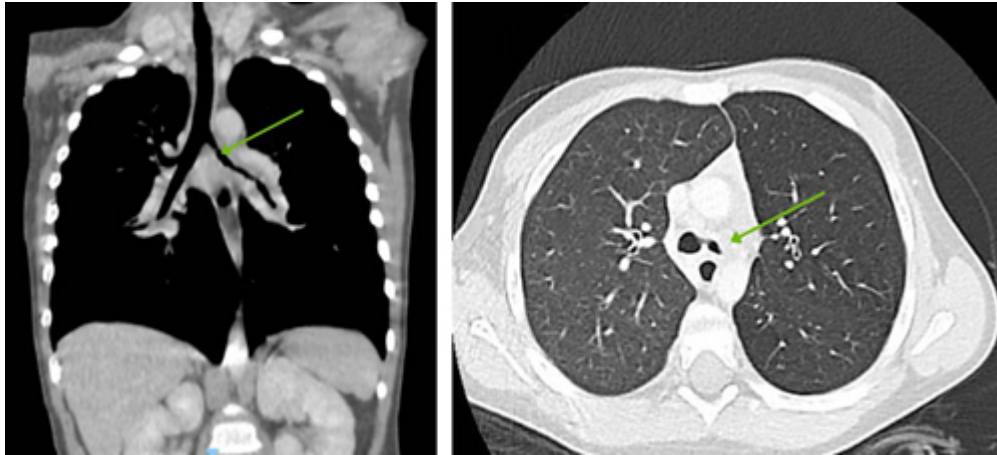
HRCT scan showed diffuse bronchial thickening with areas of parenchymal air trapping, particularly on the left side. There was a moderate reduction of approximately 50%–60% in the calibre of the left main bronchus from its tracheal origin to the lobar bronchi (arrow), with infiltration of the peribronchial tissues, without any obvious endoluminal lesion, but this cannot be confidently excluded on the CT scan alone. ↩
